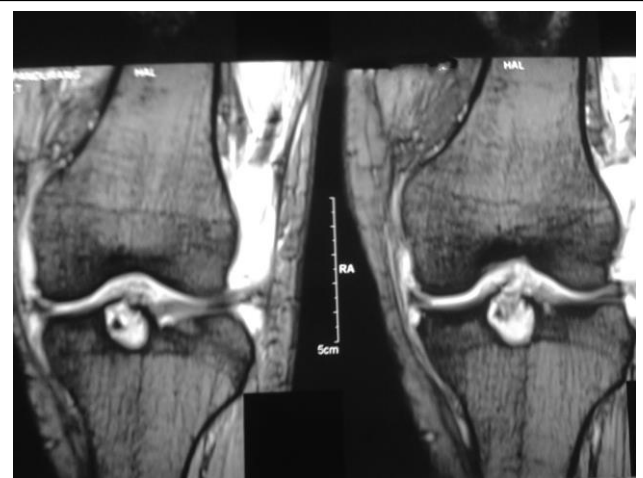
MRI of the knee joint T1 Image (a) and (b) showing intraosseous cyst.
